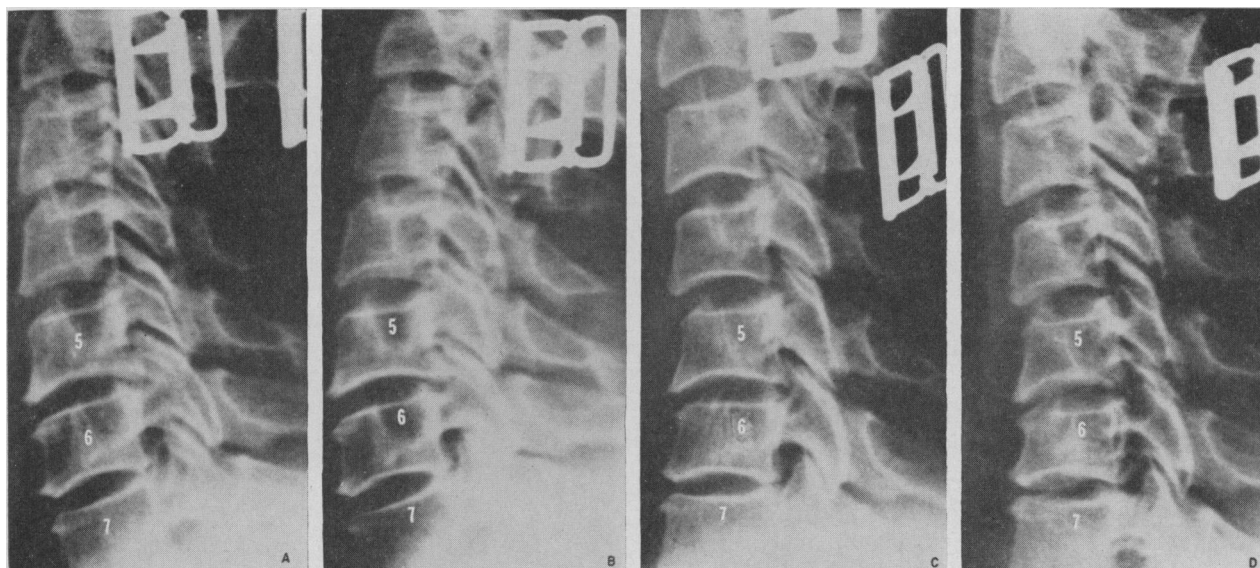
Cervical radiographs during application of traction. A. Sling in place without traction: Note the loss of cervical lordosis. B. Traction in a position of slight extension: The increased disc height is not striking but it is more noticeable at the level of the upper disc spaces. The posterior displacement of C5 on C6 appears to have been aggravated, and facet subluxation at that level has increased. No pain relief. C. Same traction as in Fig. 1 B, but in a position of flexion; the patient is turned 180° so that he is facing the door instead of turning his back to it. Pain relief was gradual and definite. The posterior displacement of C4 on C5 as well as that of C5 on C6 has been corrected, with increased disc height posteriorly; facet subluxation has also been decreased. D. Same traction as in Fig. 1 B and C with more flexion as the patient moves farther away from the door. Pain relief was complete. The C6-C7 disc space has widened and the lower intervertebral foramina are clearly visible.
